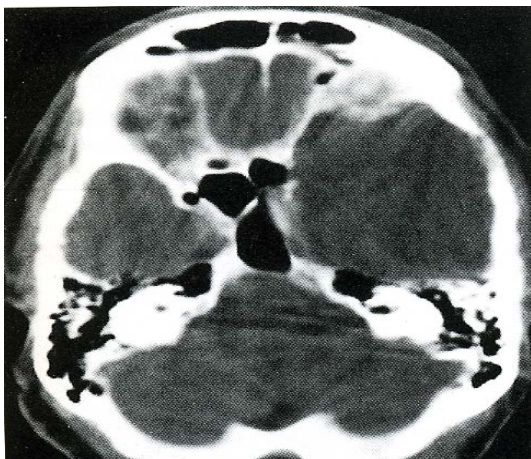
Axial brain CT scan: absent left sphenoid wing
